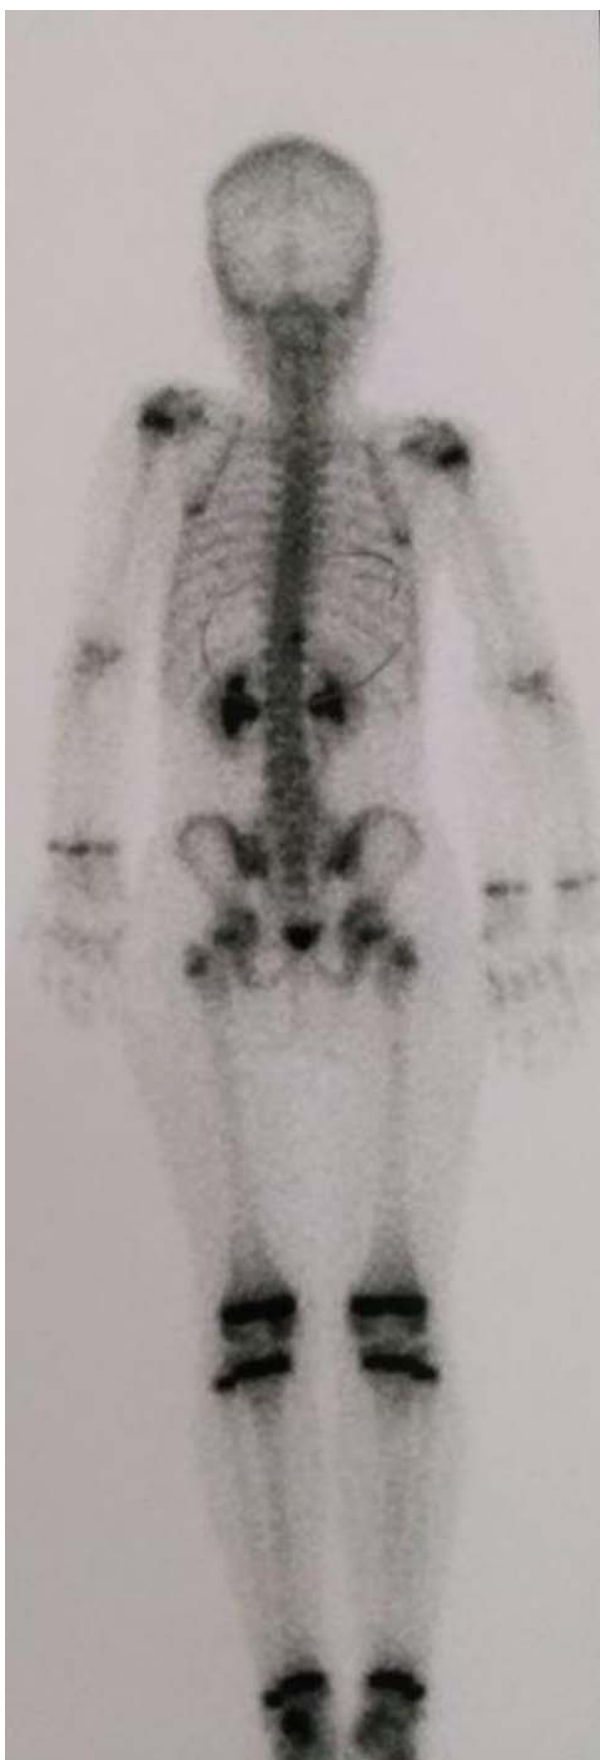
Bone scintigraphy. The image shows a slight increase in osteoblastic activity on the right edge of the T11 vertebra.
